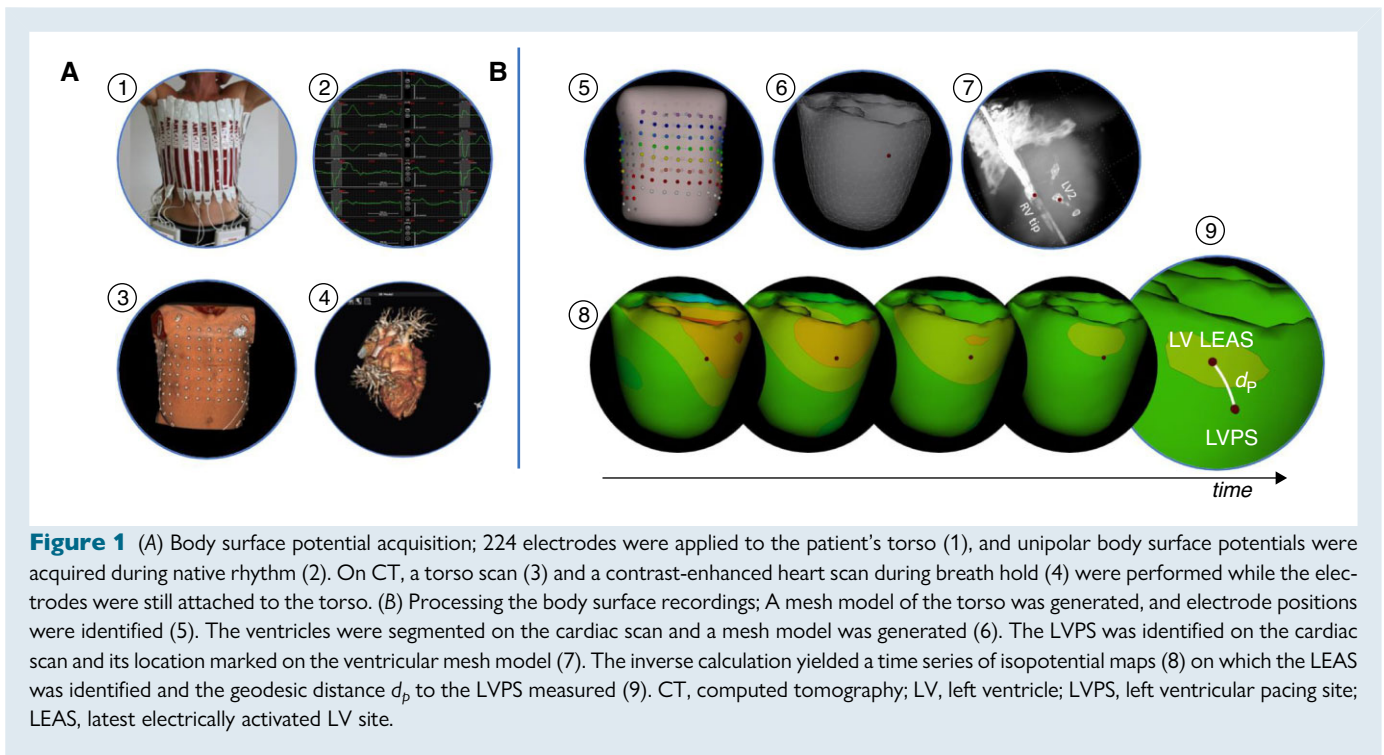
(A) Body surface potential acquisition; 224 electrodes were applied to the patient's torso (1), and unipolar body surface potentials were acquired during native rhythm (2). On CT, a torso scan (3) and a contrast-enhanced heart scan during breath hold (4) were performed while the electrodes were still attached to the torso. (B) Processing the body surface recordings; A mesh model of the torso was generated, and electrode positions were identified (5). The ventricles were segmented on the cardiac scan and a mesh model was generated (6). The LVPS was identified on the cardiac scan and its location marked on the ventricular mesh model (7). The inverse calculation yielded a time series of isopotential maps (8) on which the LEAS was identified and the geodesic distance d_p to the LVPS measured (9). CT, computed tomography; LV, left ventricle; LVPS, left ventricular pacing site; LEAS, latest electrically activated LV site.
